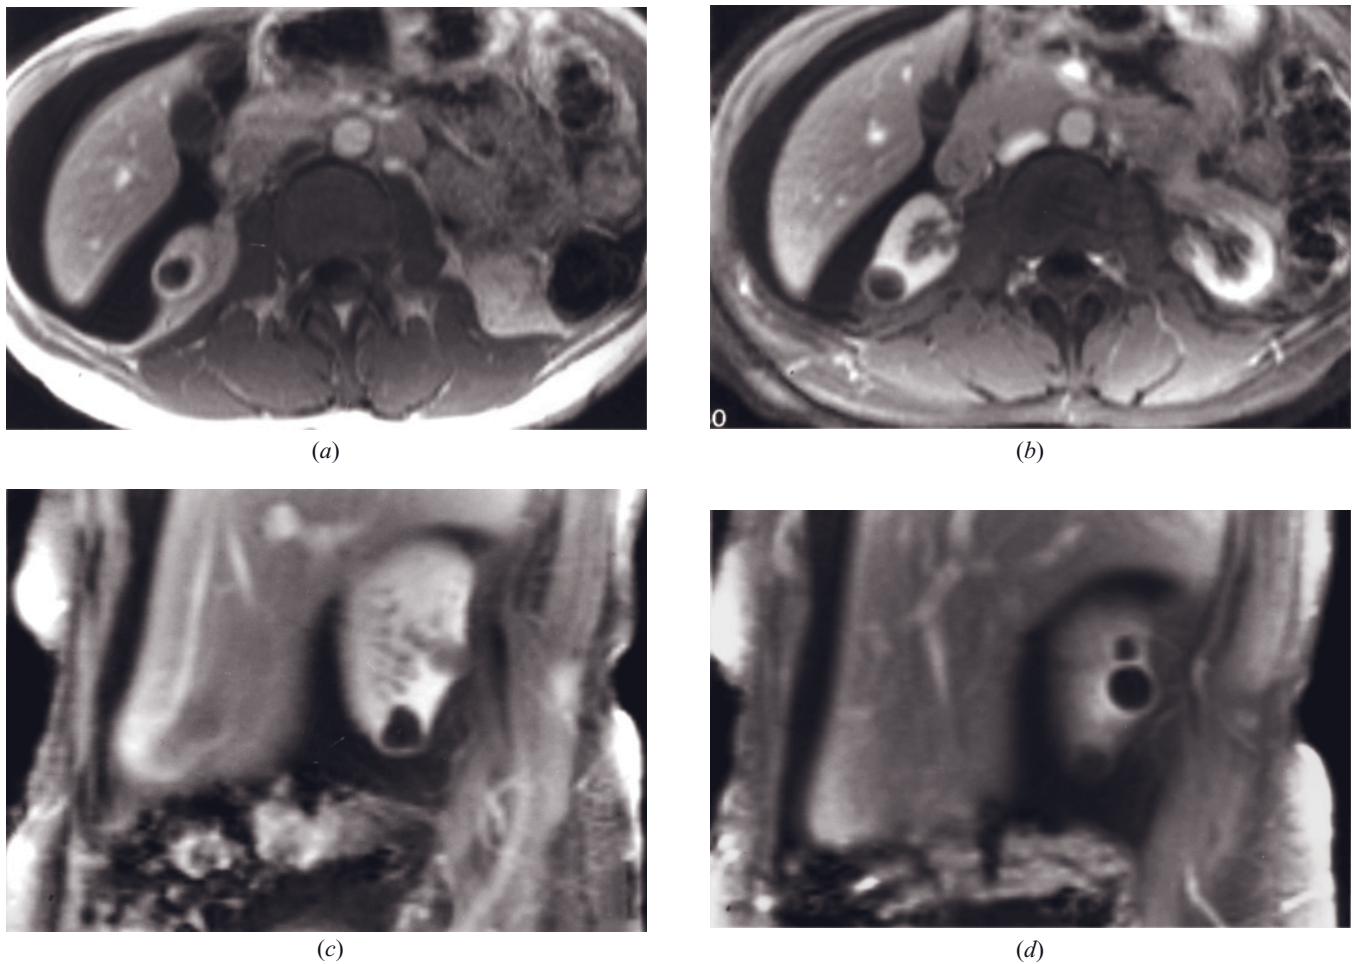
Cyst with thickened wall and reactive cellular infiltrate. Transverse T1-weighted 45-s (a) and 90-s fat-suppressed (b) postgadolinium SGE images and sagittal T1-weighted 3- to 4-min interstitial-phase (c, d) postgadolinium SGE images. Note three cysts in the right kidney with thick enhancing walls that show no mural irregularity.
